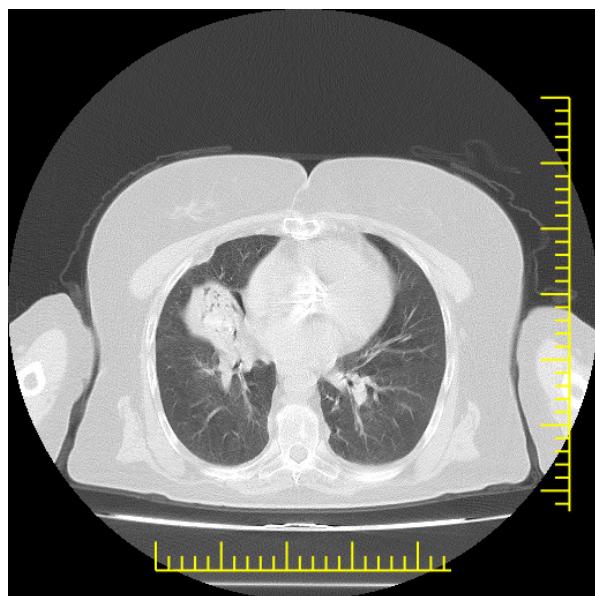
Thoracic CT showing traction bronchiectasis in the right middle lobe
